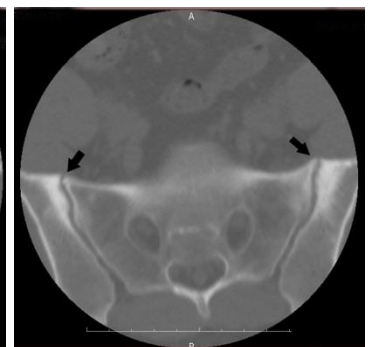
Bilateral osteitis condensans ilii in a 36 year old male patient. Bilateral-symmetrical triangular shaped sclerosis (thick arrows) on the iliac aspect of the sacroiliac joints on the axial computed tomography scan (thick arrow).
